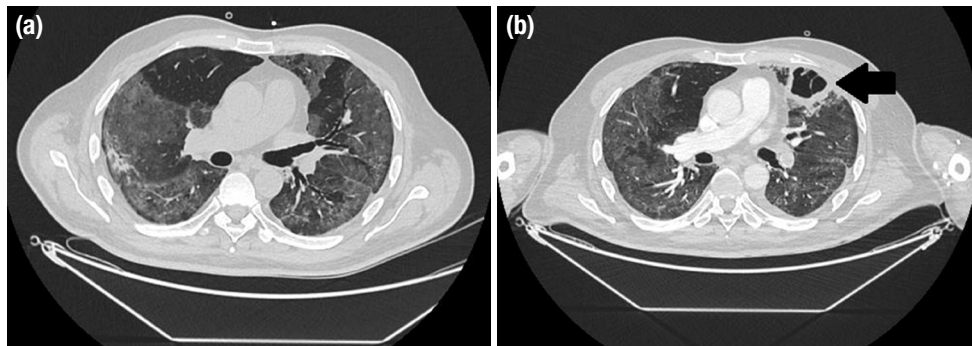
a, b. A patient who was followed in the intensive care unit due to Covid-19 pneumonia and developed a cavitary lesion in the follow-up CT. Initial (a) and approximately one month later CT examination (b, arrow).
